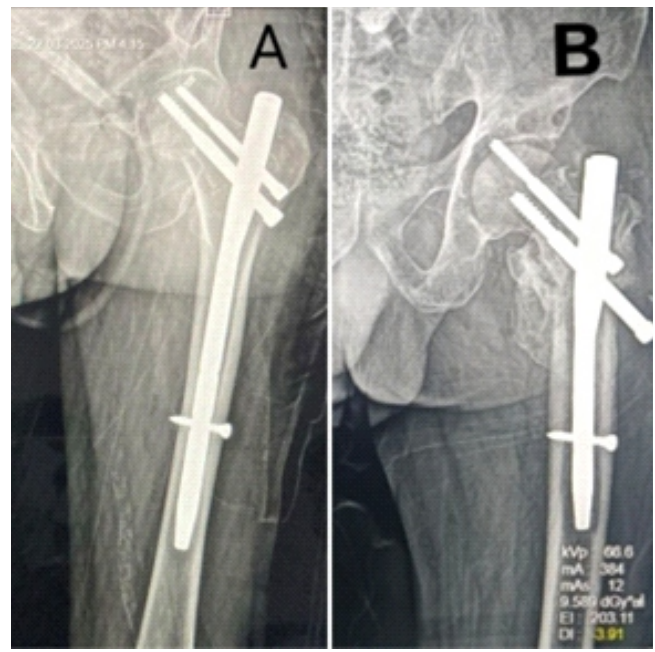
(a) Post-operative anterior-posterior (A-P) view X-ray showing pertrochanteric femur fracture of the left side fixed with a short proximal femoral nail. (b) Post-operative A-P view X-ray showing "Z" effect of proximal femoral nail.
